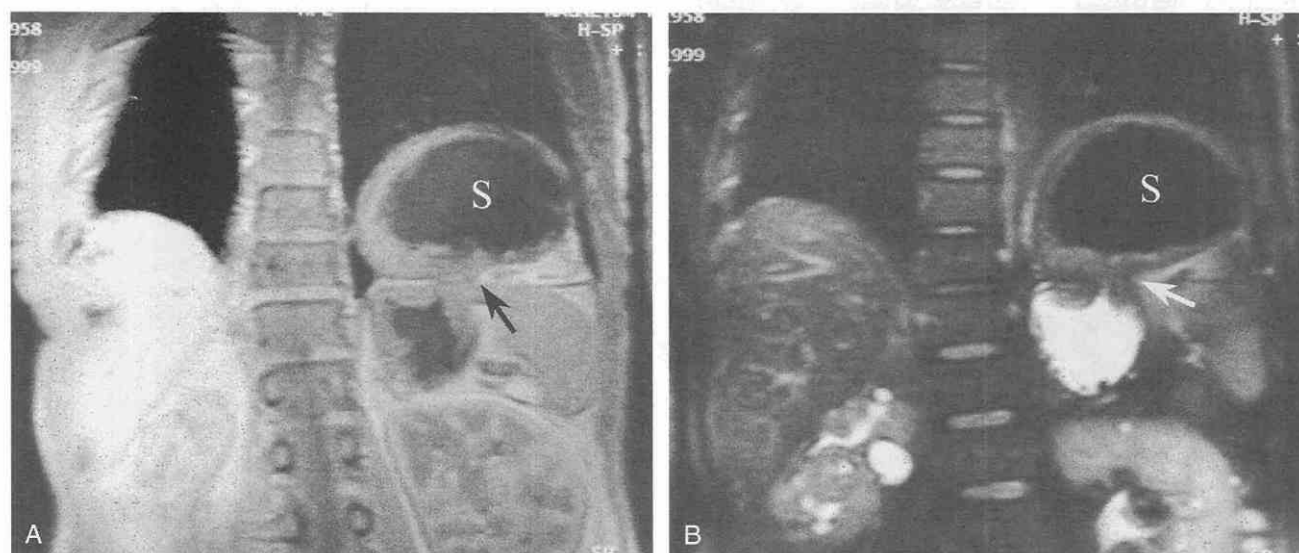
Delayed post-traumatic diaphragmatic hernia. Coronal T1-weighted (*A*) and half-Fourier acquisition single-shot turbo spin-echo (HASTE) (*B*) MR image clearly depicts gastric wasting (arrow) and the intrathoracic position of the herniated stomach (S). Note the hyperintense, thin diaphragm.
